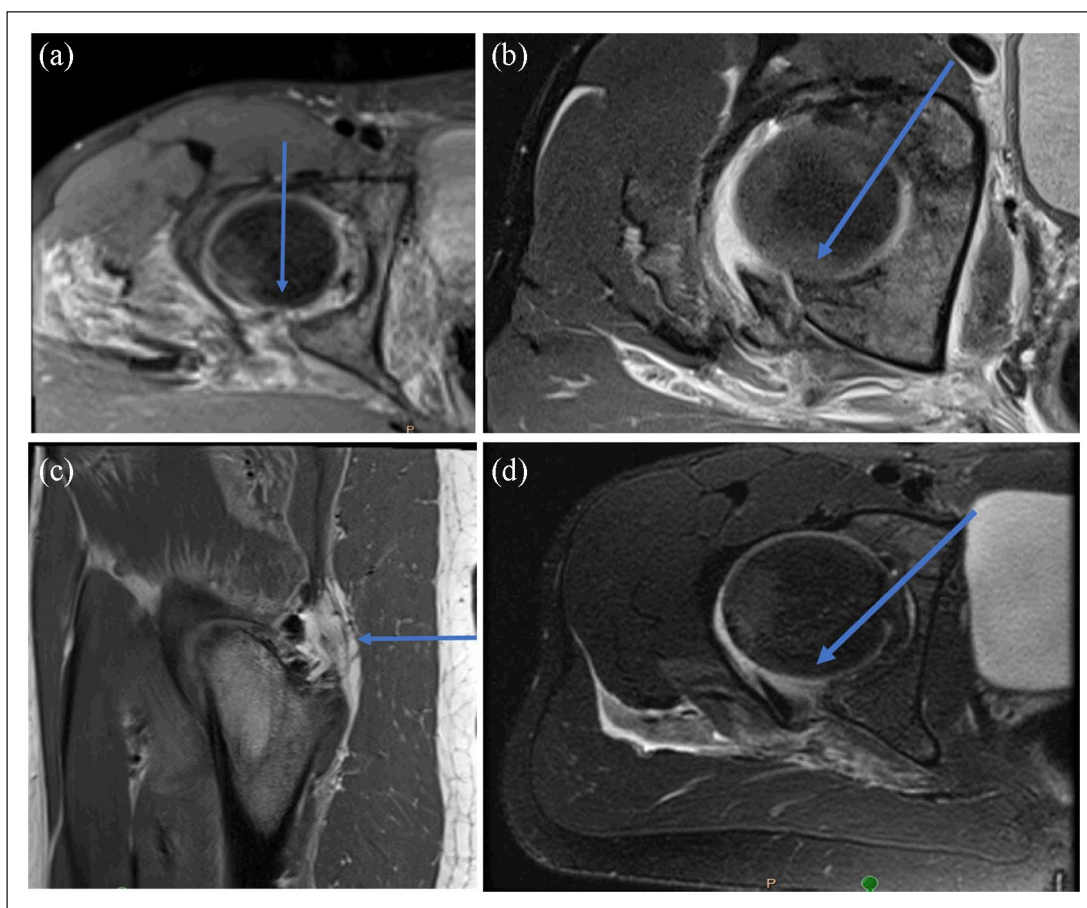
Representative slices from postreduction-MRI (injury labeled with blue arrow). (a) Labral tear. (b) Osteochondral fragments. (c) Gluteus medius tear. (d) Labral tear.
